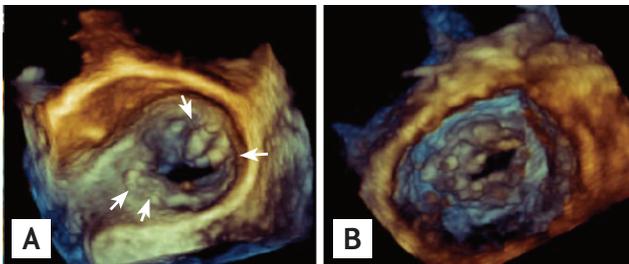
Three-dimensional transesophageal echocardiography images of a stenotic mitral valve (A) from the left atrium and (B) from the left ventricle. Arrows indicate severe calcifications.
